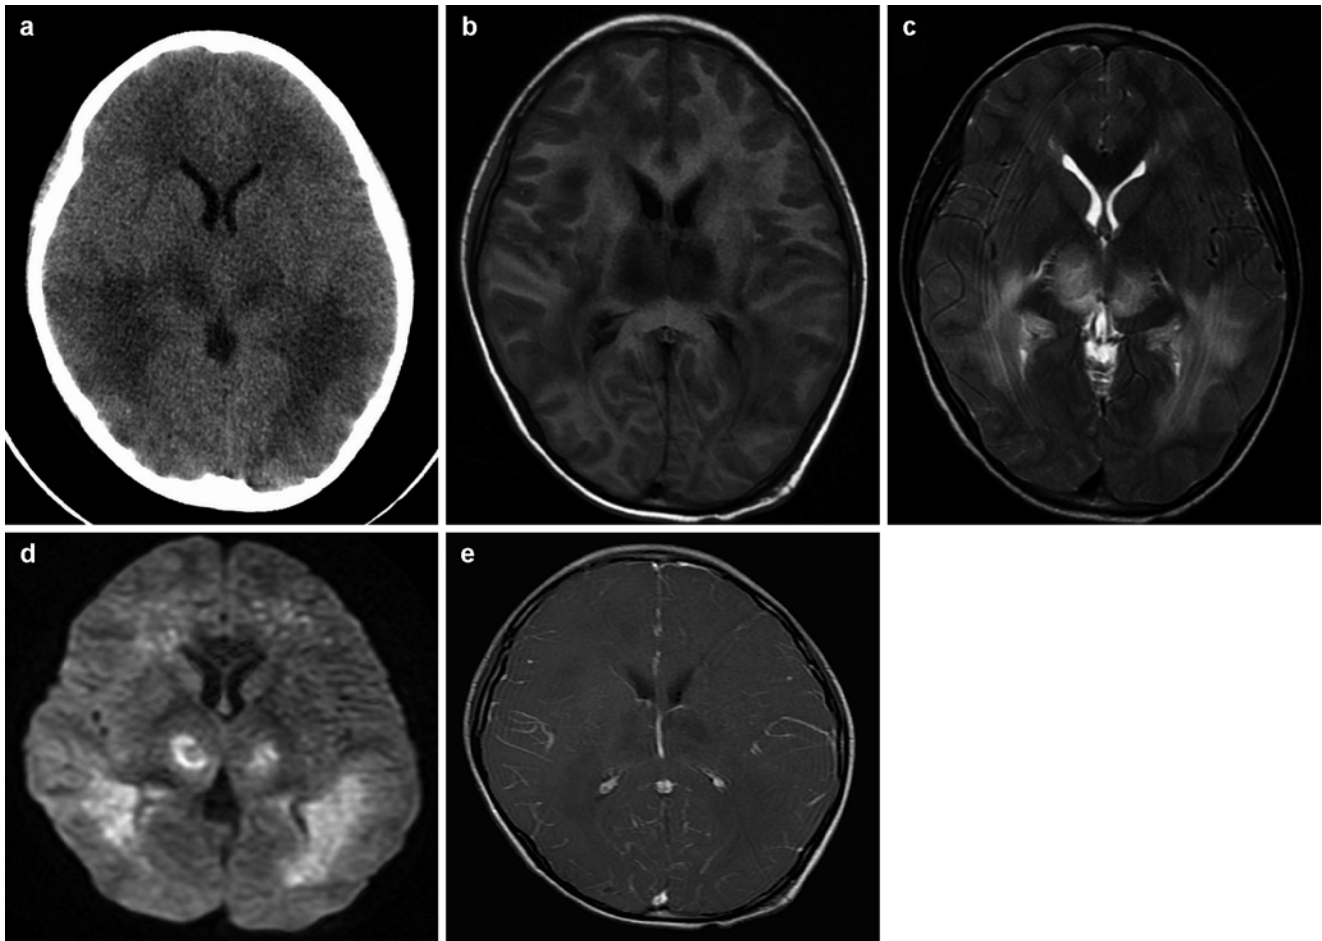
(a–e) A boy aged 9 years with influenza A (H1N1) complicated by acute necrotizing encephalopathy. At d 4 since onset, the patient received CT and MRI scans. (a) Head CT scan showed symmetric low-density opacities at the bilateral thalami, posterior limb of internal capsule, lenticular nucleus, globus pallidus, optic radiation, and frontal white matters. (b) Head MRI showed symmetric slightly low T1WI signals at the bilateral thalami, posterior
